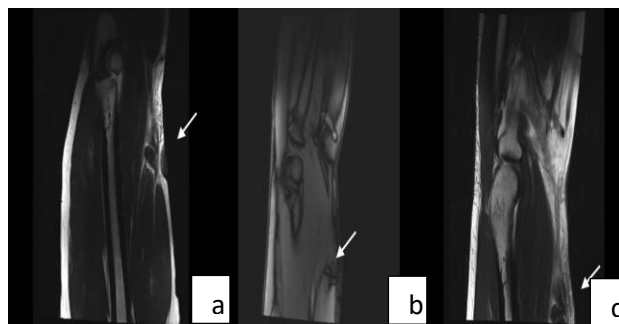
(a-c): Series of MRI images showing the complete avulsion of the biceps tendon with approximately 9cm of retraction from its insertion site with fluid pockets around the torn tendon.(white arrows).
